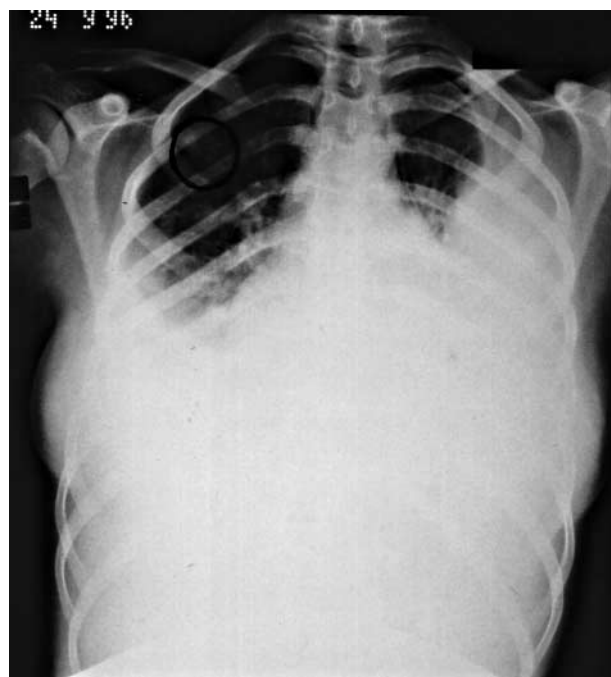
Radiograph showing bilateral empyema and cavitating lesion in right upper zone (circled)
